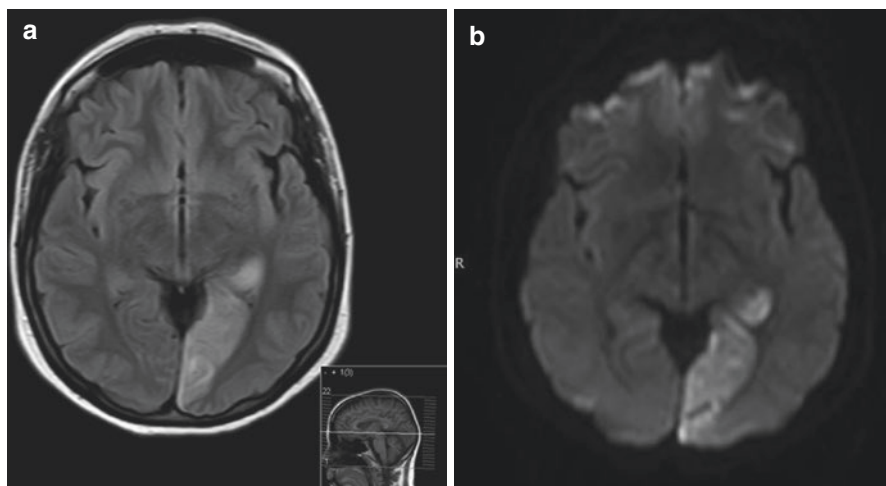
(a) T2 weighted axial MRI showing high signal within the left occipital lobe, and (b) diffusion weighted MRI showing restricted diffusion within the same area, in keeping with a recent onset infarction
